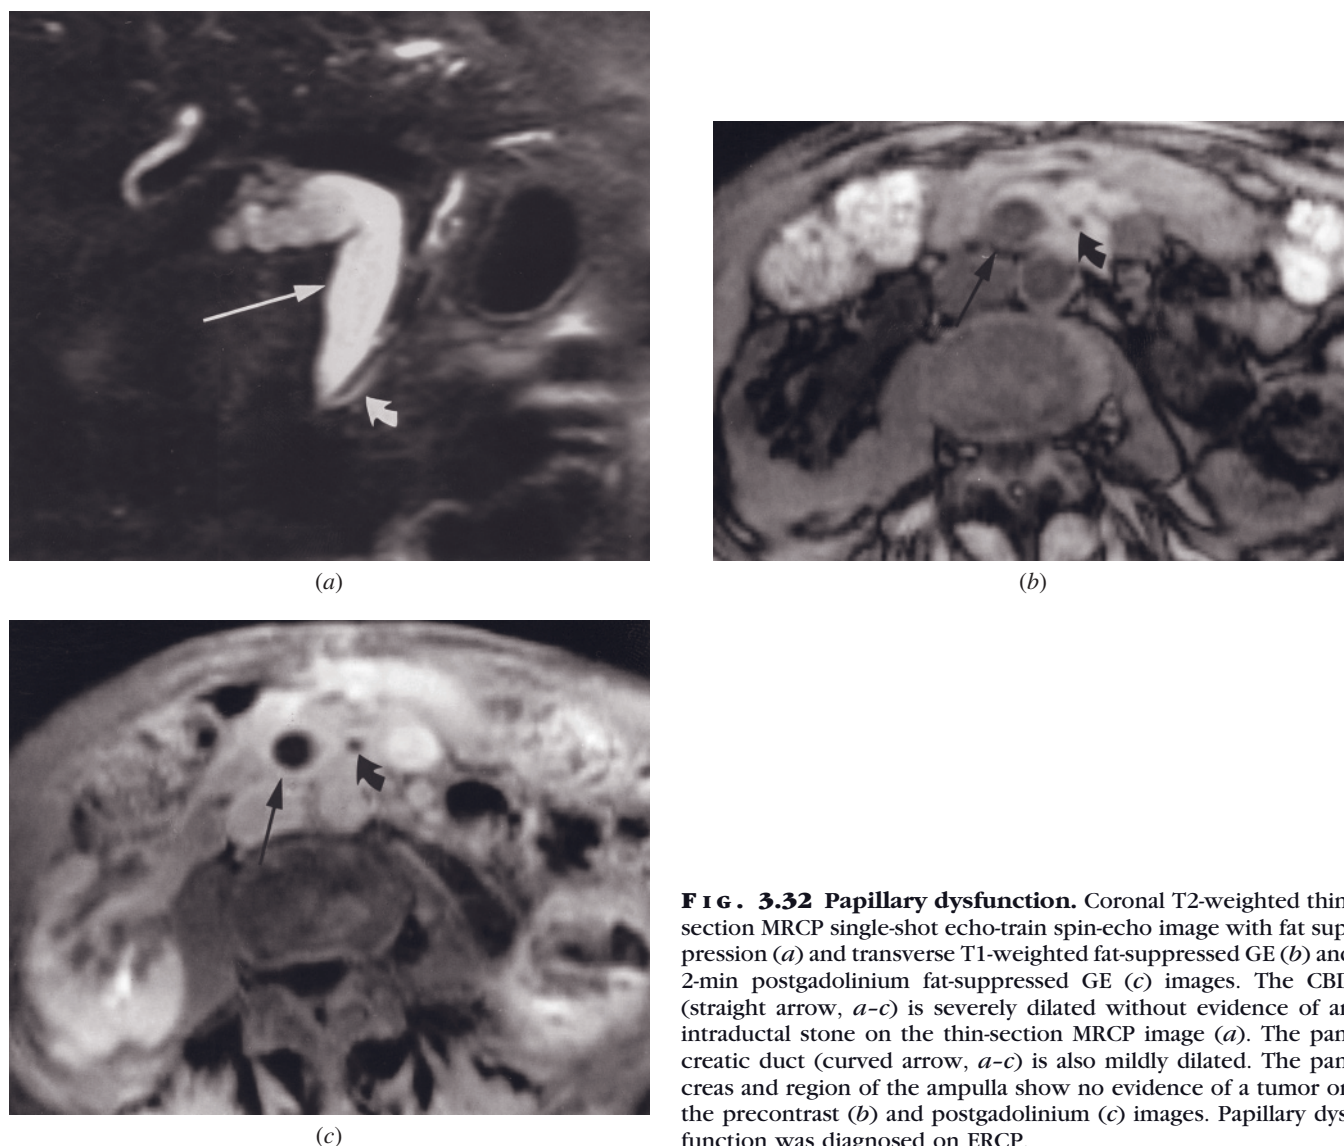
Papillary dysfunction. Coronal T2-weighted thin-section MRCP single-shot echo-train spin-echo image with fat suppression (*a*) and transverse T1-weighted fat-suppressed GE (*b*) and 2-min postgadolinium fat-suppressed GE (*c*) images. The CBD (straight arrow, *a-c*) is severely dilated without evidence of an intraductal stone on the thin-section MRCP image (*a*). The pancreatic duct (curved arrow, *a-c*) is also mildly dilated. The pancreas and region of the ampulla show no evidence of a tumor on the precontrast (*b*) and postgadolinium (*c*) images. Papillary dysfunction was diagnosed on ERCP.
